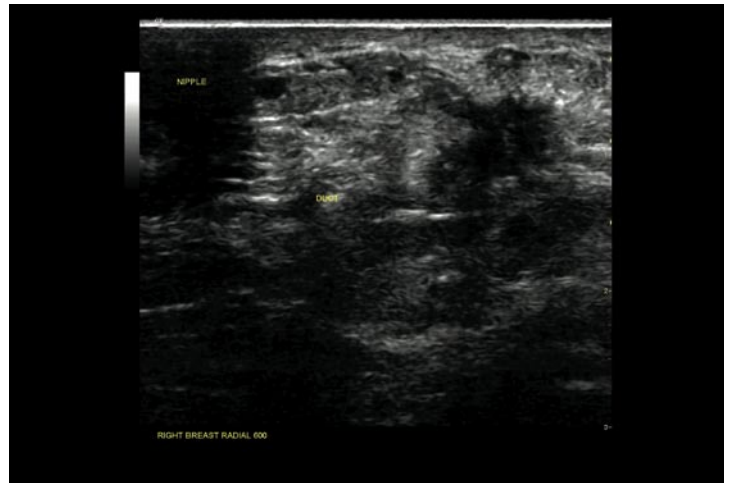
Right breast view shows ductal involvement of DCIS. (Proven later by ultrasound guided core biopsy)
